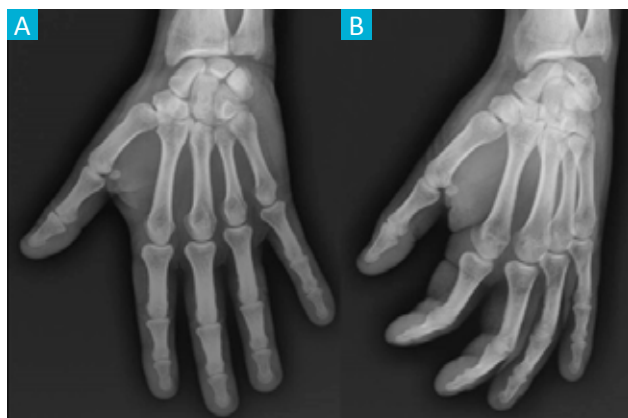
Left hand radiographs at presentation in anteroposterior (A) and oblique (B) projections. Both were inconclusive, showing no obvious fractures and intact trapeziometacarpal joint.
